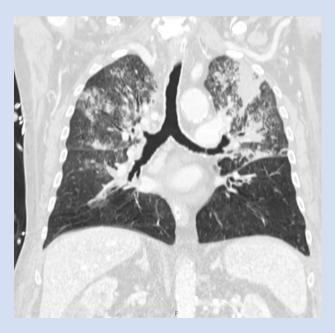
Chest computed tomography scan performed before ICU admission
